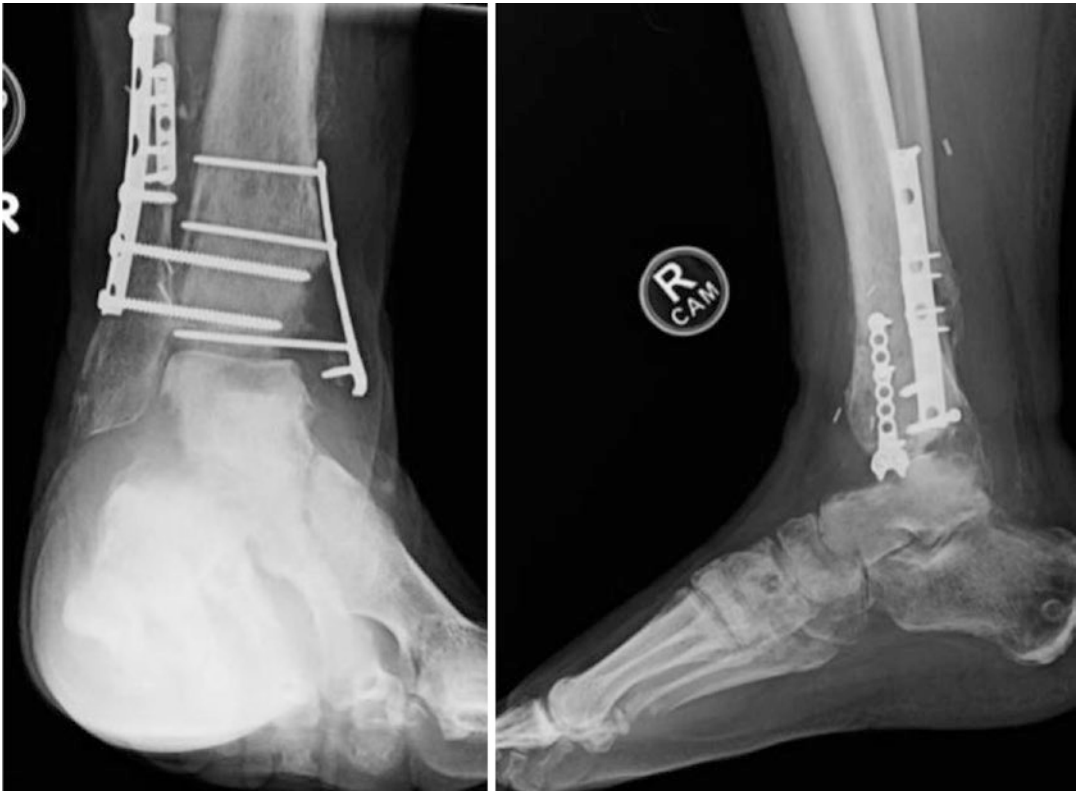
AP and lateral radiographs 4 months after injury demonstrate further bony resorption and in the setting of a clinically diagnosed deep infection. The patient
